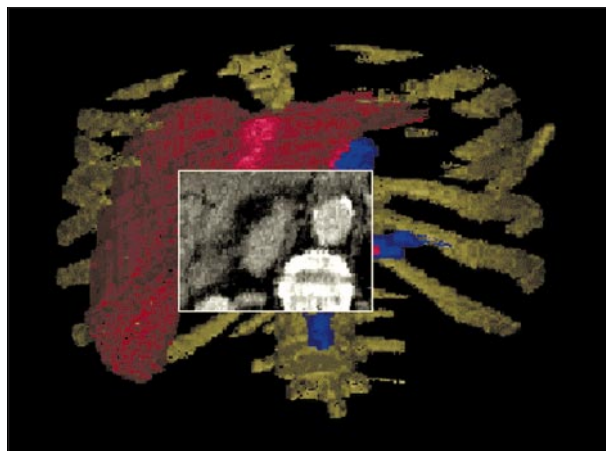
The 3-dimensional reconstruction tool bidirectional enhanced rendering for telemedical applications (BERTA) visualizes computed tomographic, magnetic resonance imaging, and ultrasound scans stereoscopically. In a region of interest, the original computed tomographic data are shown. (Source: OP 2000 Surgical Research Unit OP 2000, Robert-Rössle-Klinik am Max-Delbrück-Centrum, Berlin, Germany.)
